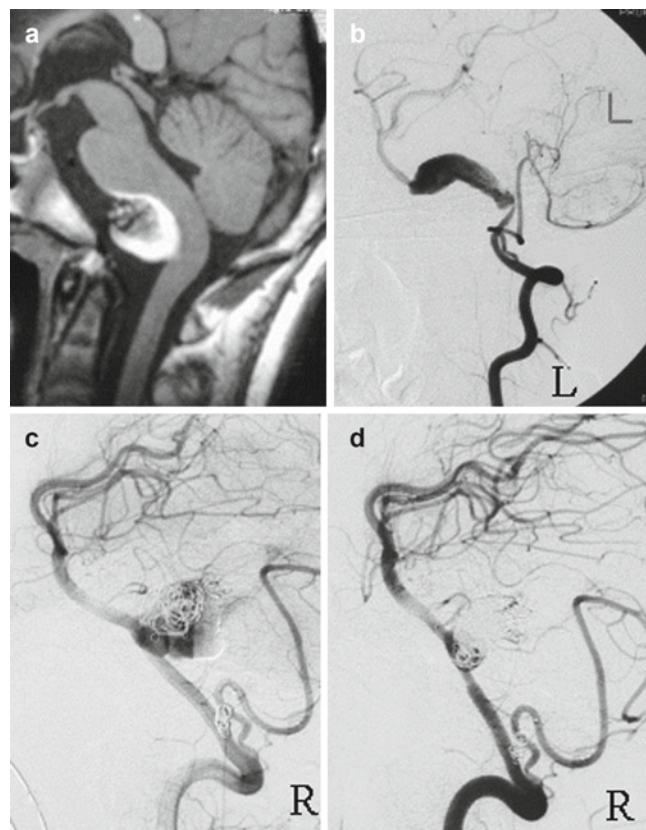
Coil occlusion of a fusiform vertebral artery aneurysm left with brainstem compression. MRI with partially thrombosed aneurysm before intervention (a), vertebral DSA left before coil occlusion (b) and vertebral DSA right before a second intervention with recanalization and widening of aneurysm (c). After stent application via the vertebral artery right, and repeat coil occlusion of the distal aneurysmal segment (d)
